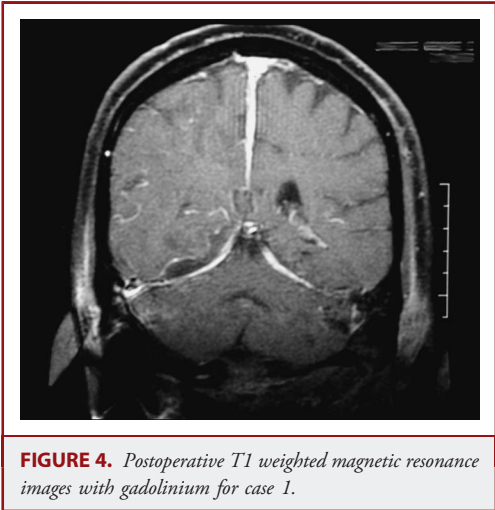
Postoperative T1 weighted magnetic resonance images with gadolinium for case 1.
